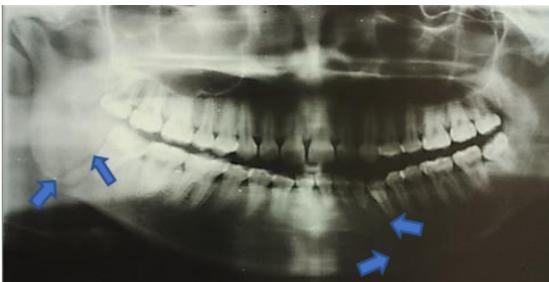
Pre-operative Panoramic Radiograph showing fractures present at right angle and left parasymphysis area
